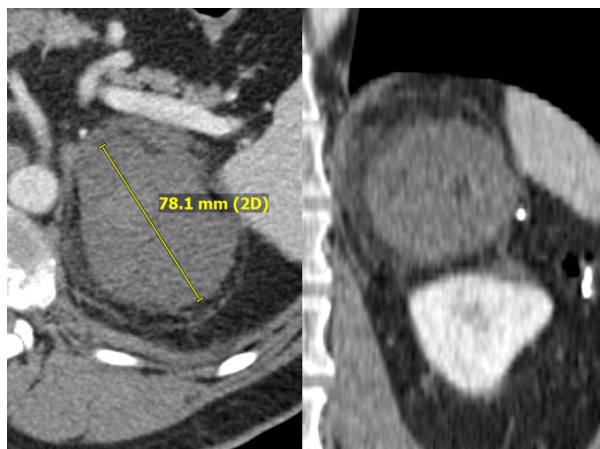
Axial and coronal image from 9-month post-procedure CT scan demonstrating left adrenal RCC metastasis without residual enhancement, now measuring 7.8 cm.
